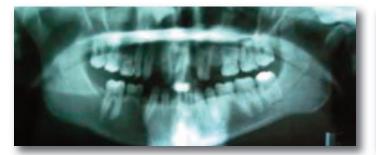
Panoramic radiograph displaying missing permanent dentition and inadequate root spacing for implants.
